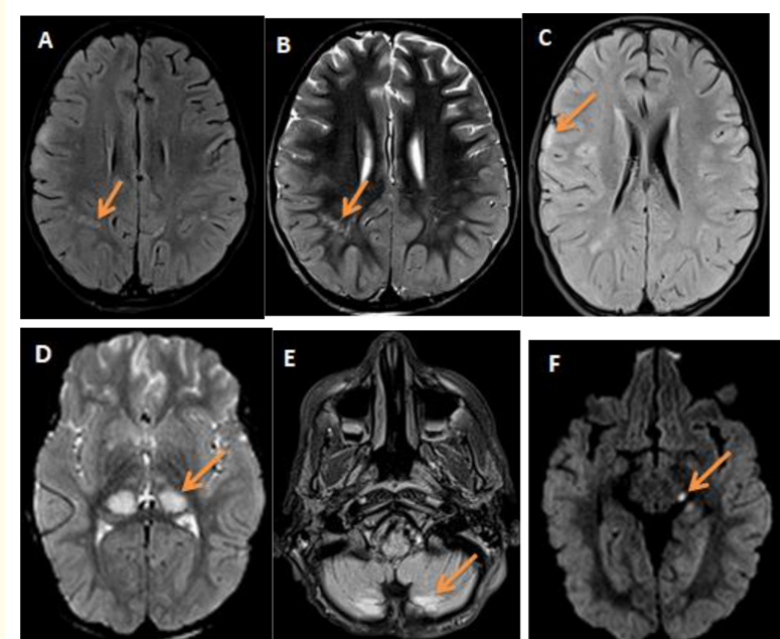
Axial MRI sequences showing bilateral and asymmetric supratentorial and subtentorial nodular and patchy signal abnormalities, T2 and Flair hypersignal, of the subcortical white matter (FLAIR/ T2 sequence (A/B)) cortical (FLAIR sequence (C)), temporal, thalamic (diffusion sequence (D)) putaminal, cerebellar (FLAIR sequence (E)) and left mesencephalic (diffusion sequence (F)). These lesions have a diffusion restriction (diffusion sequence (D/F)). They are not enhanced after injection of Gadolinium.
